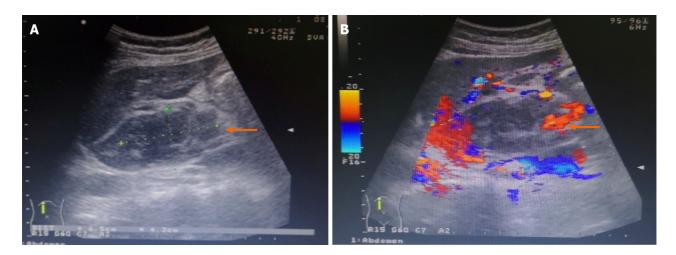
Ultrasound examination of the liver and gallbladder. A: A hypoechoic mass is seen in the caudate lobe of the liver, being about 6.5 cm × 4.3 cm in size, with blurred boundary and irregular shape; B: No obvious blood flow signal is seen in this mass, which had prompted consideration of the possibility of a malignant tumor.
